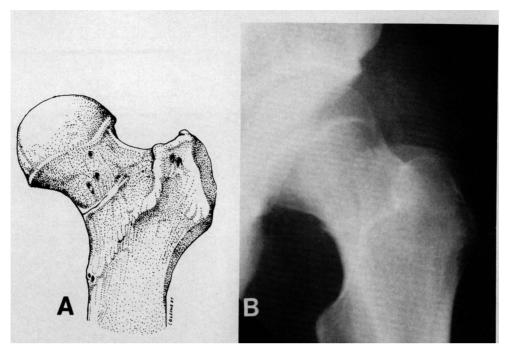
A, cortical crack in a compression-side femoral neck stress fracture. B, radiograph showing a compression-side stress fracture with an undisplaced cortical crack.
